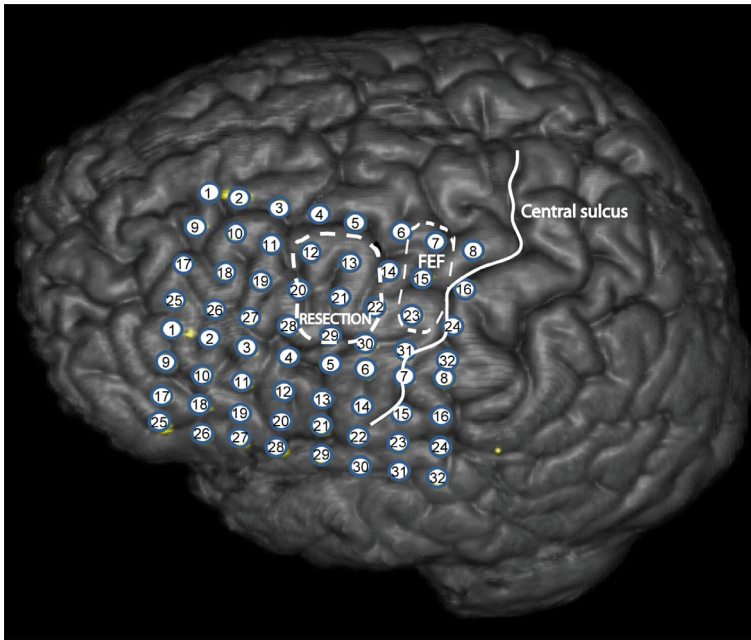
Rendering of a pre-implantation anatomical T1-weighted MRI scan of the patient's brain with the positions of the grid electrodes superimposed. [Colour figure can be viewed at wileyonlinelibrary.com]
